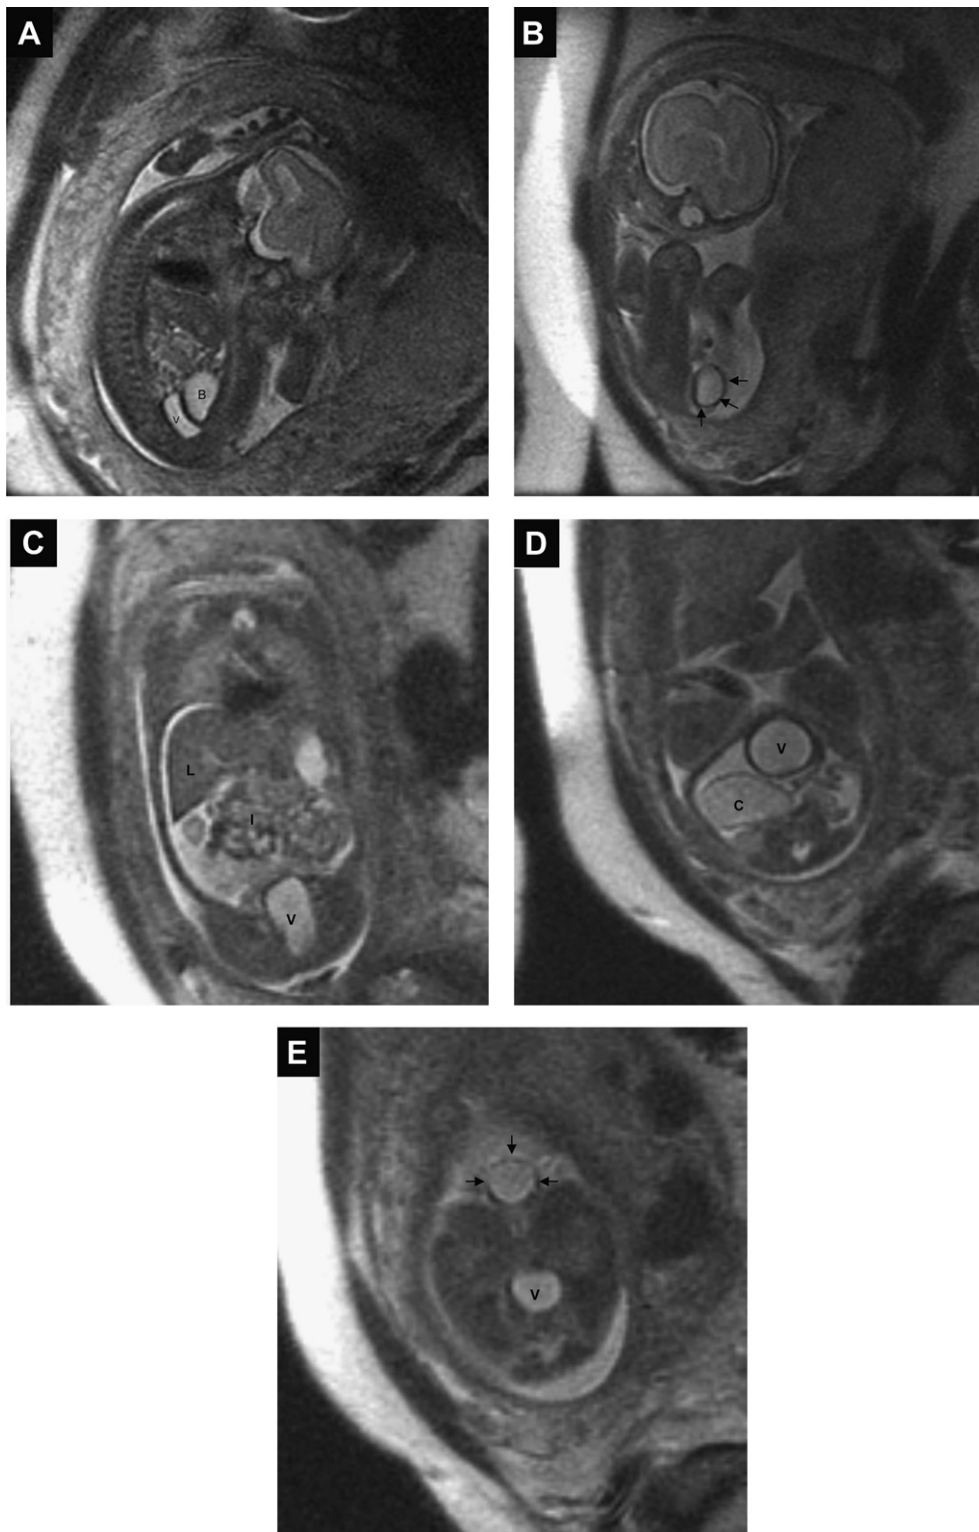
Fetal magnetic resonance imaging at 24 weeks of gestation shows (A) dilated bladder and vagina (sagittal scan), (B) a perineal cyst (arrows) (coronal scan), (C) ascites and a dilated vagina (coronal scan), (D) dilated distal colon and vagina (axial scan), and (E) dilated vagina and a perineal cyst (arrows) (axial scan). B = bladder; C = colon; I = intestines; L = liver; V = vagina.
